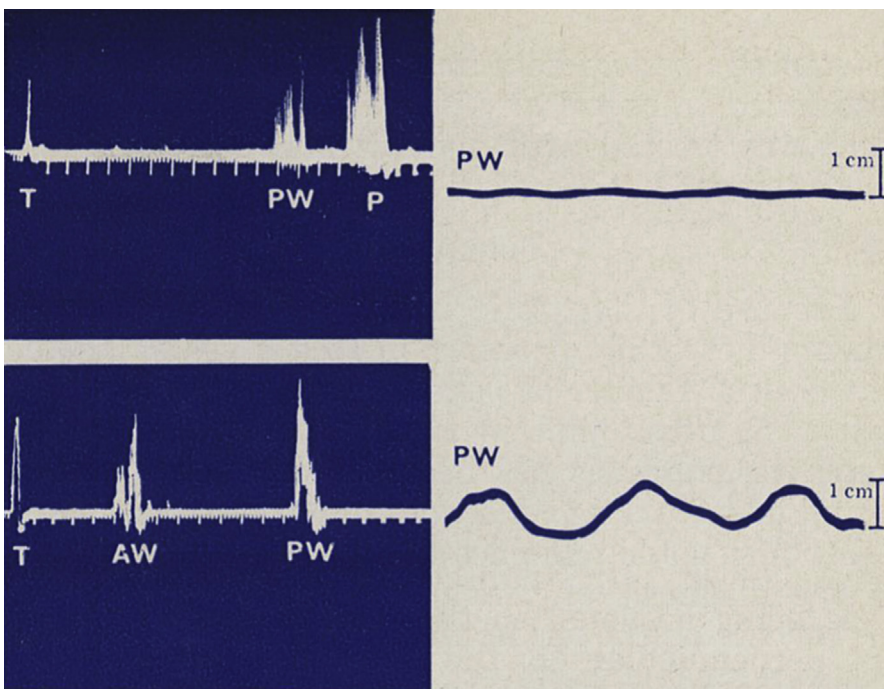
(Top) A-mode echocardiography detecting pericardial effusion between posterior wall (PW) and the pericardium (P). The systolic and diastolic motion of PW is lost. (Bottom) After draining of pericardial effusion, the space is no longer present and the motion of PW is restored. (From Feigenbaum H, Waldhausen JA, Hyde LP. Ultrasound diagnosis of pericardial effusion. JAMA 1965;191:713; with permission.)
